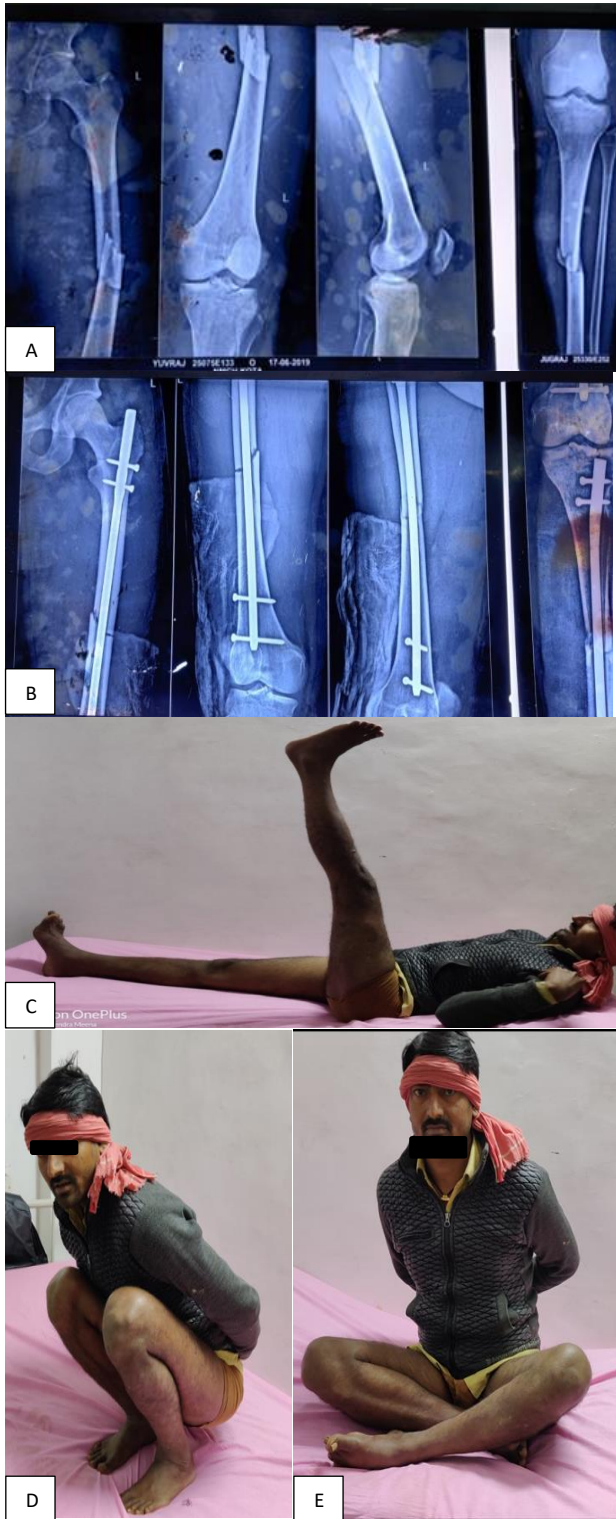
(A-E): Pre-op x-ray, post op x-ray and straight leg rising, knee banding and cross leg sitting.
